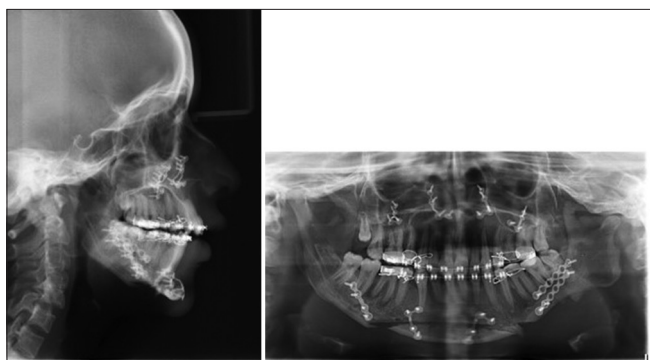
Radiograph on the day of debonding
